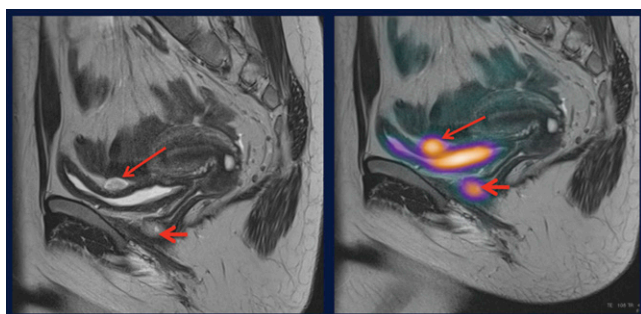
Images acquired in a 16-year-old girl with suspected recurrence after resection of paraganglioma. (A) Sagittal T2WI MR. (B) Sagittal ^{68}Ga -DOTATATE PET and T2WI MR fused. The 2 foci (arrows) were not seen on the original PET/CT.
